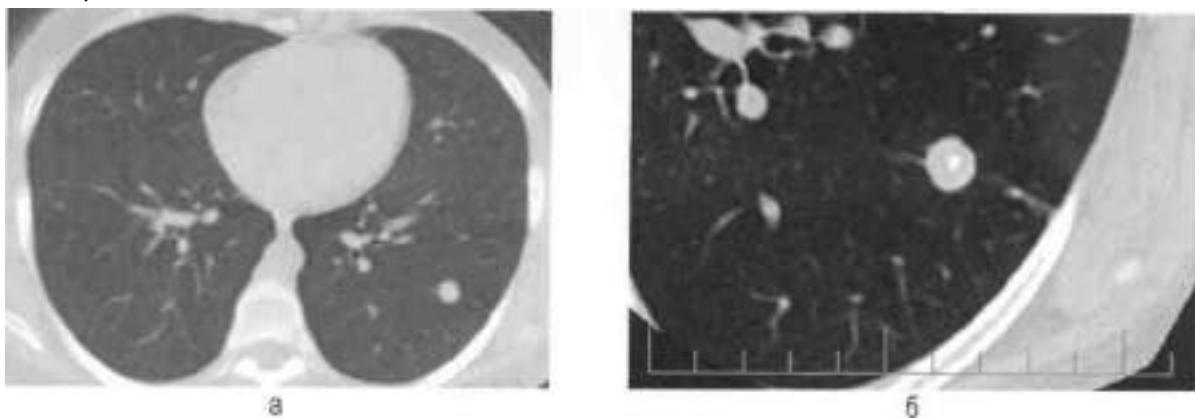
Tuberculoma S₍₆₎ of the left lung. The focal shadow is 1,2 cm in diameter and has clear, even contours. The surrounding tissue is unchanged (a). With bolus administration, the contrast agent accumulates in the capsule and creates a rim enhancement effect (targeted reconstruction of the left lung, high-resolution CT) (b).
